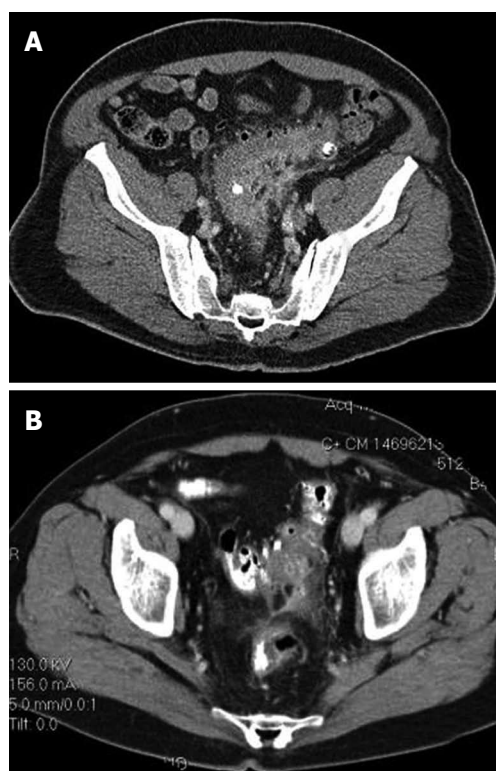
Computed tomography (CT) imaging demonstrating acute diverticulitis. A: Computed tomography (CT) imaging demonstrating acute, uncomplicated diverticulitis. Reproduced with permission from Stocchi L. Current indications and role of surgery in the management of sigmoid diverticulitis. *World J Gastroenterol* 2010; 16(7): 804-817; B: CT imaging demonstrating acute diverticulitis with localized perforation with a small amount of extraluminal air. Reproduced with permission from Stocchi L. Current indications and role of surgery in the management of sigmoid diverticulitis. *World J Gastroenterol* 2010; 16 (7): 804-817.
